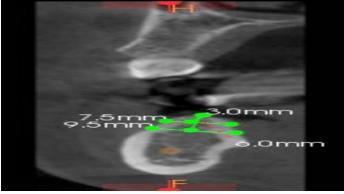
Measurement of alveolar bone height and width using CBCT
